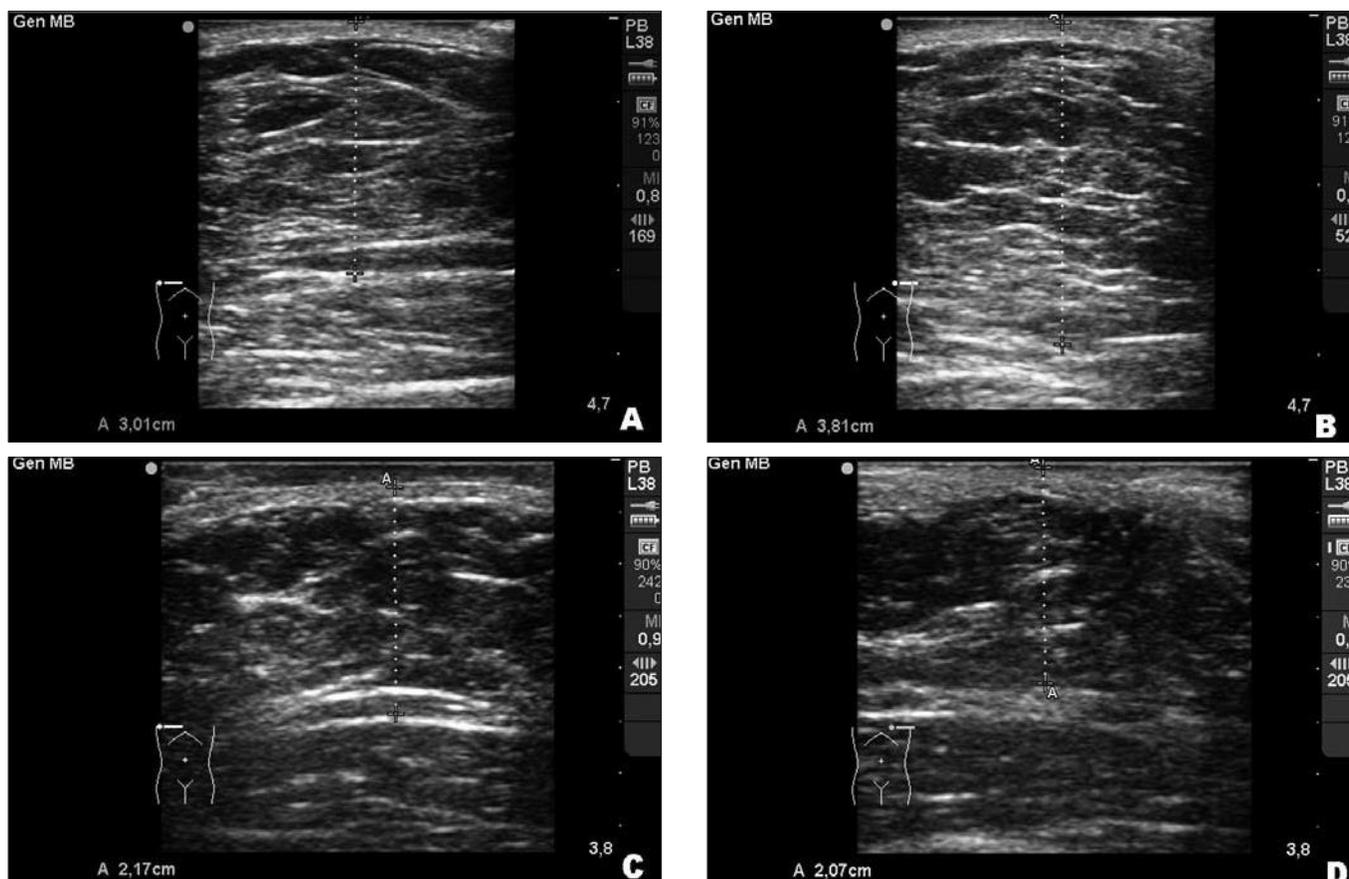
Ultrasonography of the patient of Figure 1. A. Right breast before laser lipolysis; B. Left breast before laser lipolysis; C. Right breast 6 months after the surgery; D. Left breast 6 months after surgery. In both ultrasonography tests we can observe a decrease in adipose tissue and an increase in the thickness of the dermis.
